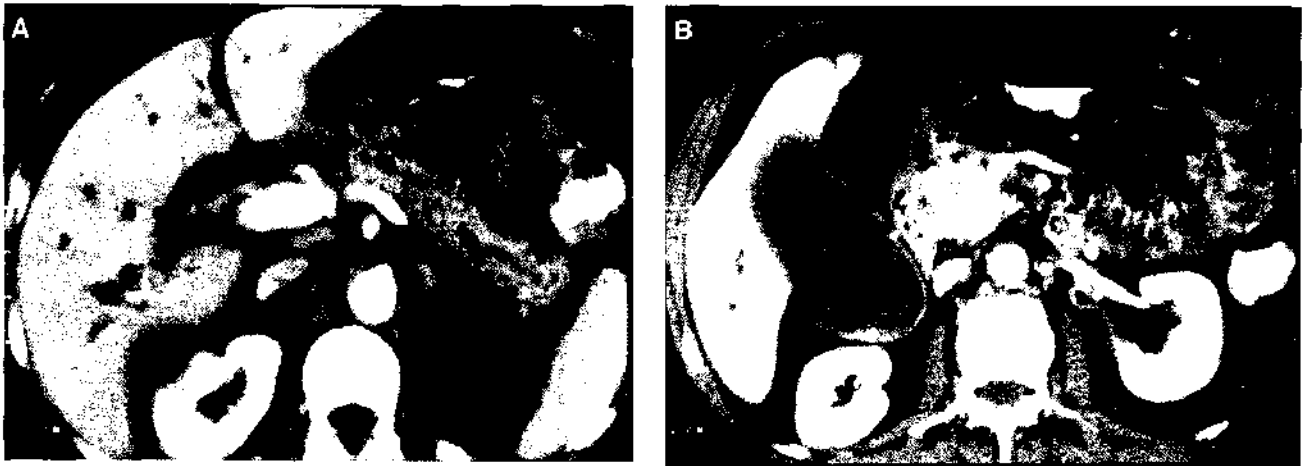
(A) CT scan showing both common bile duct and pancreatic duct dilation (double duct sign) in a patient with adenocarcinoma of the pancreatic head. (B) Note the massively enlarged, easily palpable gallbladder (Courvoisier's gallbladder).
